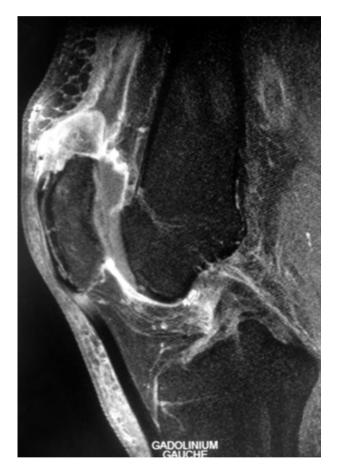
MRI findings in a chronic tear of the quadriceps tendon
